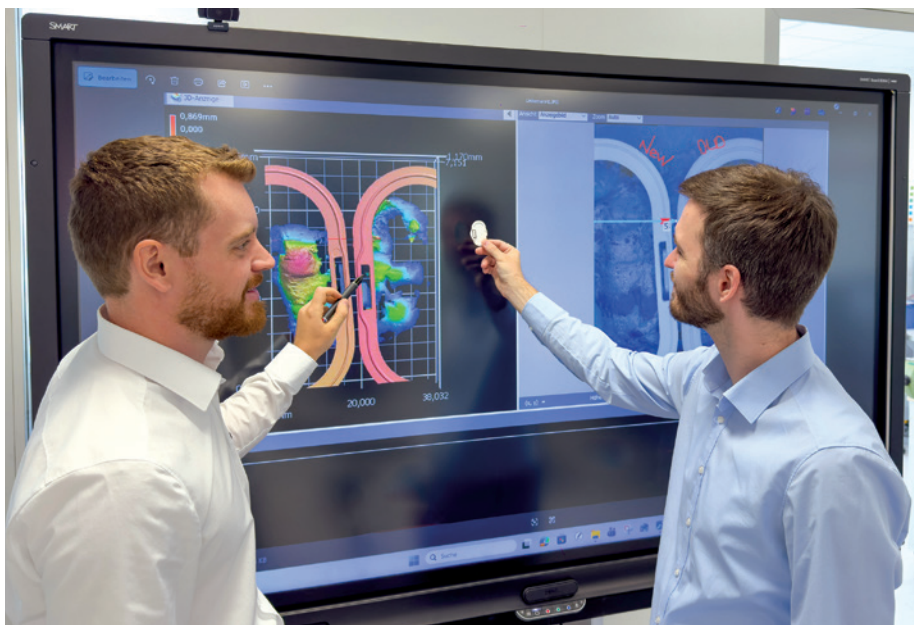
With the consulting provided by Herrmann's application engineers, the product design was slightly adjusted to make it ideal for ultrasonic bonding.
